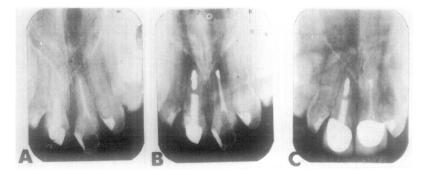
Case 3. Maxillary right and left central incisors of 30-year-old white woman. Root canal and restorative treatment (acrylic crowns) was done 3 years previously by general dentist. No root canal therapy had been performed on maxillary left central incisor. Patient refused conventional retreatment. A, Preoperative radiograph showing apical bony lesion on maxillary right central incisor. Patient has pain, buccal swelling, and percussion sensitivity on both teeth. B, Immediate postoperative radiograph shows retrograde amalgams on both teeth. C, Recall radiograph 1 year later shows asymptomatic teeth with complete apical bony regeneration. Teeth have been restored with new crowns.
